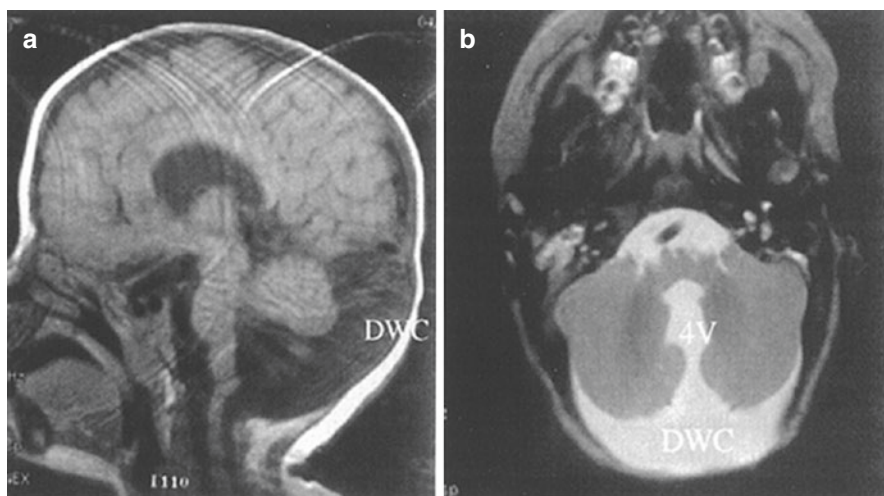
Dandy-Walker variant. (a) T1-weighted midline sagittal image shows expanded posterior fossa containing cerebrospinal fluid (CSF) and small superiorly rotated vermis. The CSF collection represents a Dandy-Walker cystic malformation (DWC) of the posterior fossa. (b) This T1-weighted axial image demonstrates the connection of the posterior fossa Dandy-Walker cystic (DWC) fluid collection with the fourth ventricle (4V)
